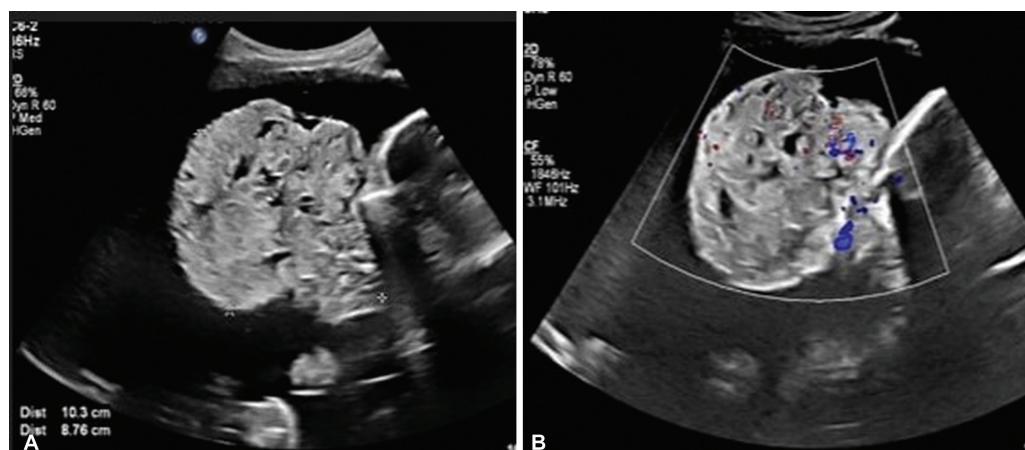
Ultrasound done at 30 weeks showing (A) increase in the size of mass to 10.3 × 8.7 cm with (B) minimal internal vascularity associated with polyhydramnios (AFI: 40 cm).
